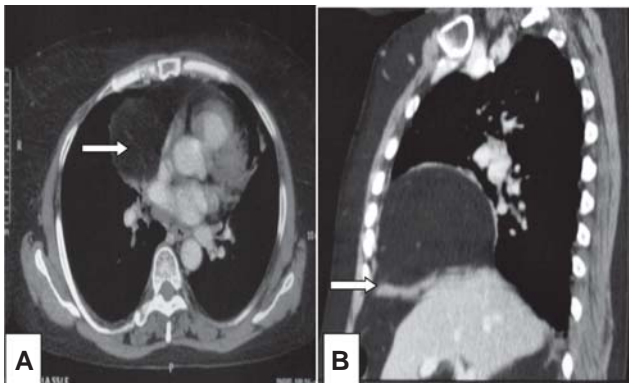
Contrast enhanced computed tomography of the chest (A) (axial section) showing prominent fat in the right paracardiac region (arrow) and (B) (sagittal reconstruction) showing a possible diaphragmatic defect (arrow).
